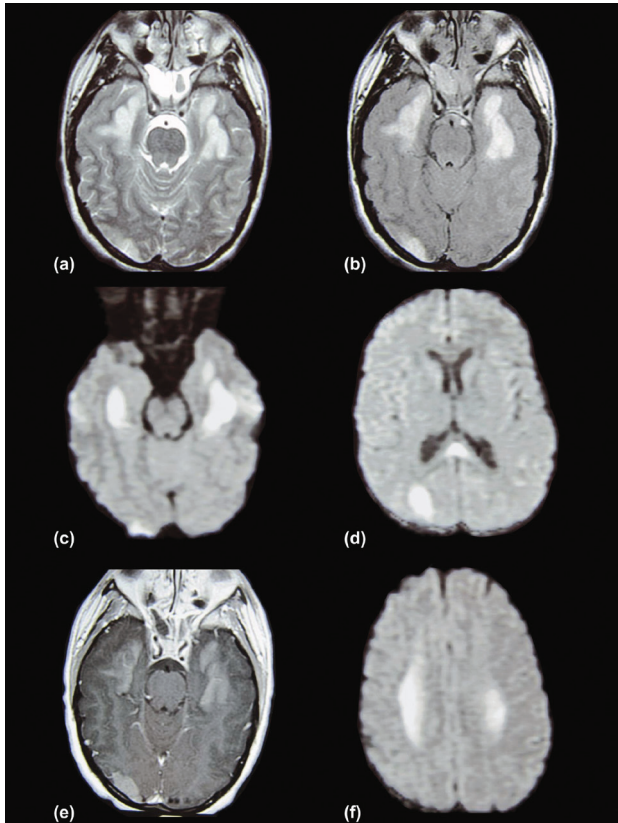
Initial MRI: (a) Axial T2-weighted (T2W) image, (b) Axial fluid attenuation inversion recovery (FLAIR) image, (c) Axial diffusion weighted image (DWI), (d) Axial DWI image, (e) Contrast-enhanced axial T1W image, (f) Axial DWI image.
